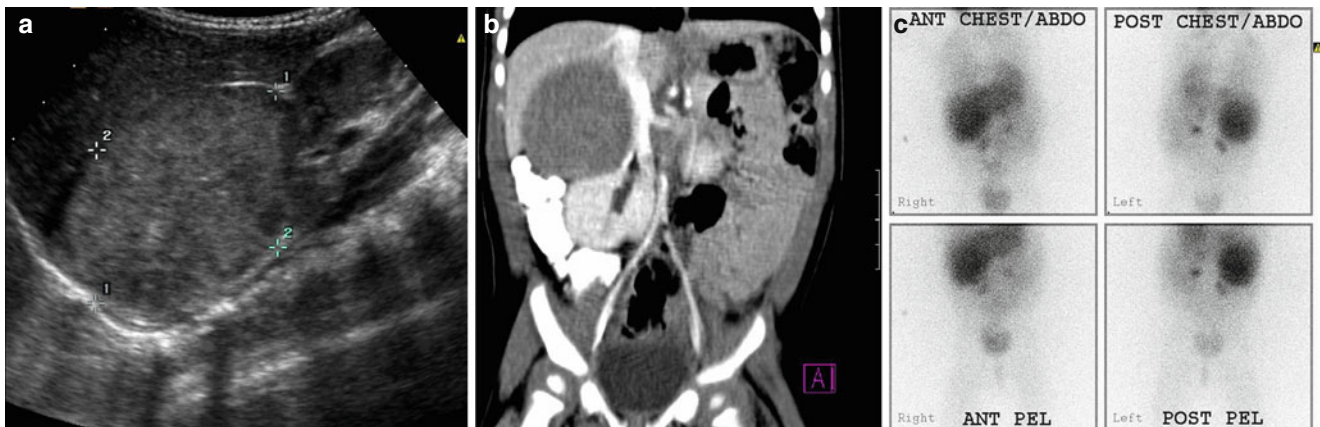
Neuroblastoma. (a) Classic appearance on ultrasound with a tumor arising from the right suprarenal area, pushing up on the under surface of the liver and displacing the right kidney inferiorly. (b) CT with contrast reconstructed in the coronal plane confirming the right
